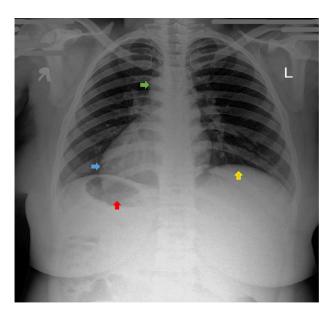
Chest radiograph demonstrating the cardiac apex on the right side (blue arrow), left-sided ascending aorta and right-sided aortic knuckle (green arrow) with a gastric bubble on the right (red arrow) and left-sided hepatic shadow (yellow arrow).
